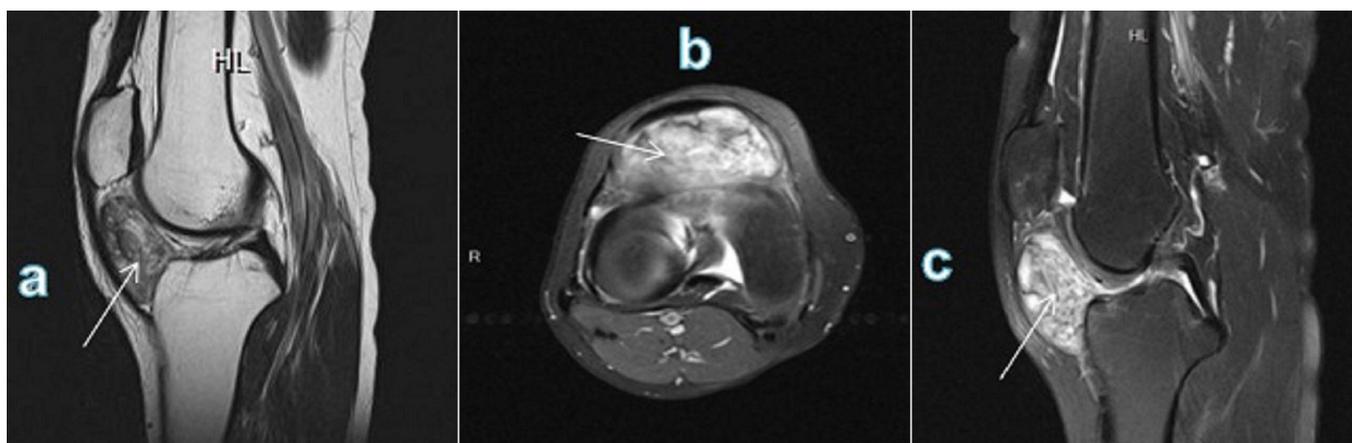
(a) Sagittal (b) and axial T2 fat-saturated MRI of the affected knee demonstrated a heterogeneous intermediate signal mass in the infrapatellar fat pad with (C) heterogeneous high and intermediate signal on T1.
